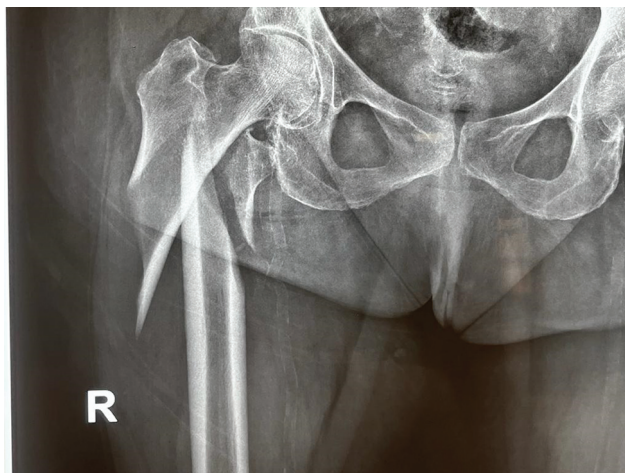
Preoperative X-ray show subtrochanteric femur fracture with displaced sharp fragment of the lesser trochanter.
